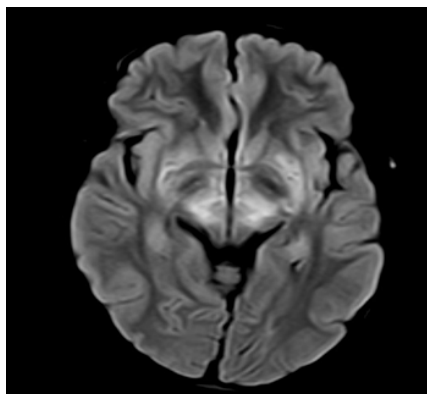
MRI showing, Axial FLAIR image through the caudate nuclei shows bilateral symmetric hyperintensity extending into the periventricular white matter, reflecting advanced disease.
